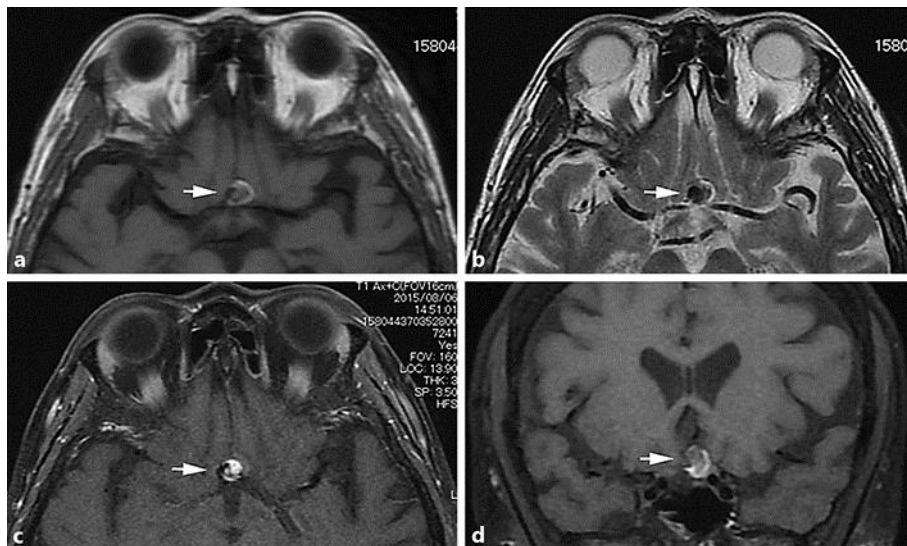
Axial T1-weighted (a) and axial T2-weighted (b) magnetic resonance images, axial T1-weighted magnetic resonance images with gadolinium enhancement (c), and coronal T1-weighted magnetic resonance images with gadolinium enhancement (d). Inside the aneurysm (indicated by an arrow in each image), a heterogeneous pattern of intensities exists with partial gadolinium enhancement.
